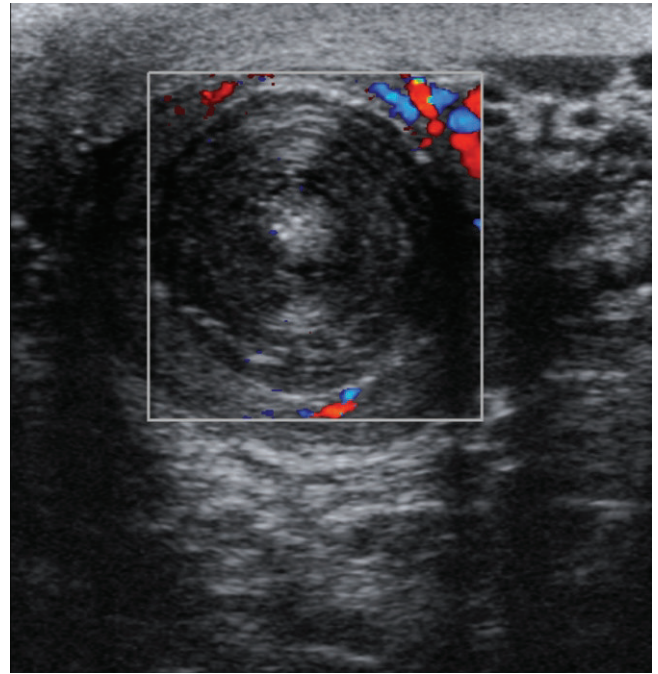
Transverse image of the left testicle with Doppler demonstrates no internal vascularity and minimal peripheral vascularity.
